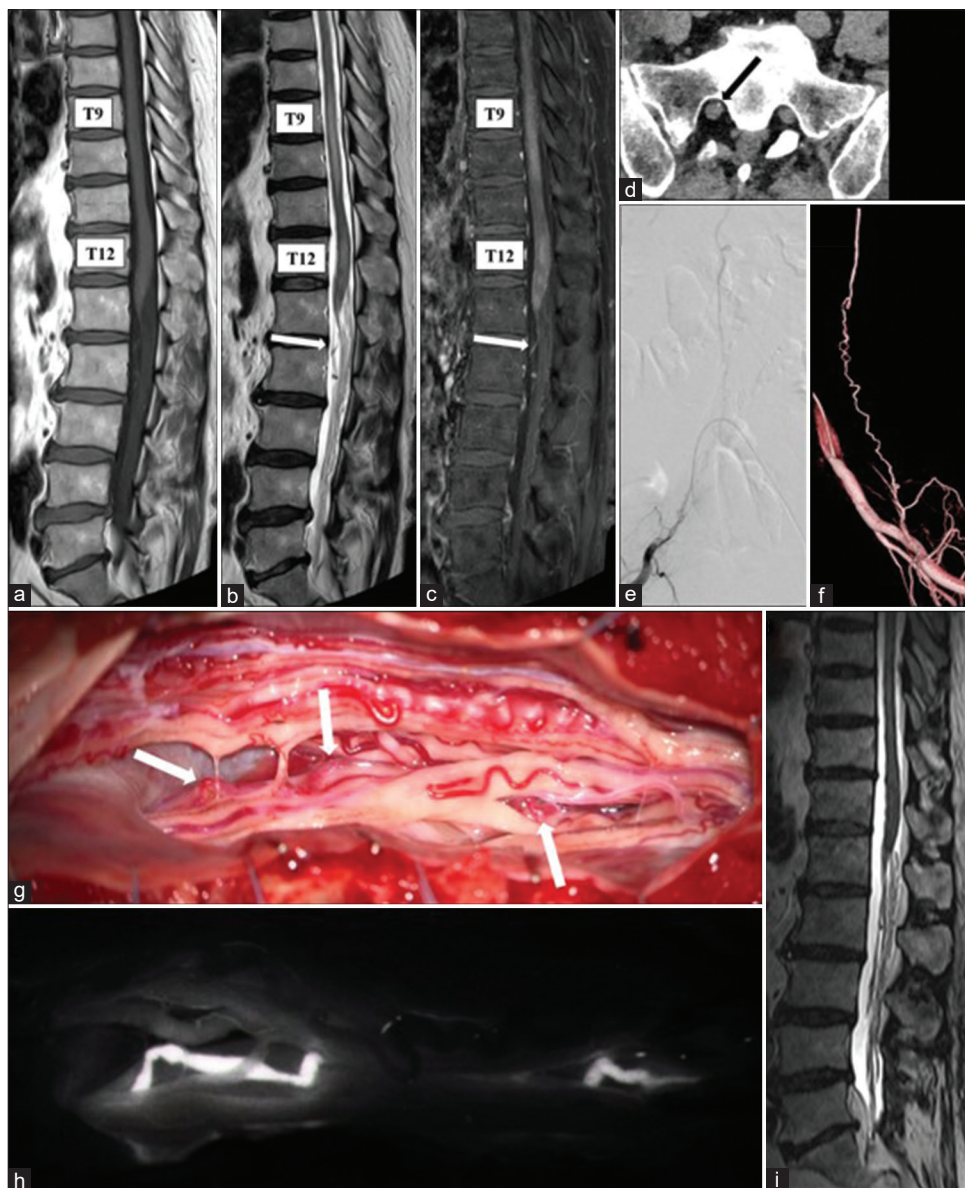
(a) T1-weighted sequence, (b) T2-weighted sequence, and (c) post-gadolinium T1-weighted sequence – initial magnetic resonance imaging at a local hospital, showing intramedullary edema at T9–10 and T12 levels and a mildly dilated vessel at the cauda equina level (white arrow) without perimedullary vein enlargement. (d) Contrast-enhanced computed tomography image at our hospital, demonstrating a dilated vessel in the right first sacral foramen (black arrow). (e and f) Right internal iliac artery angiograms, showing sacral arteriovenous fistula supplied by the right lateral sacral artery. (g and h) Intraoperative photos showing an arterialized vein (white arrows) along the S1 nerve root visualized early by the indocyanine green without other shunt vessels. (i) Magnetic resonance imaging 5 months after surgery, showing extinguished intramedullary edema.
